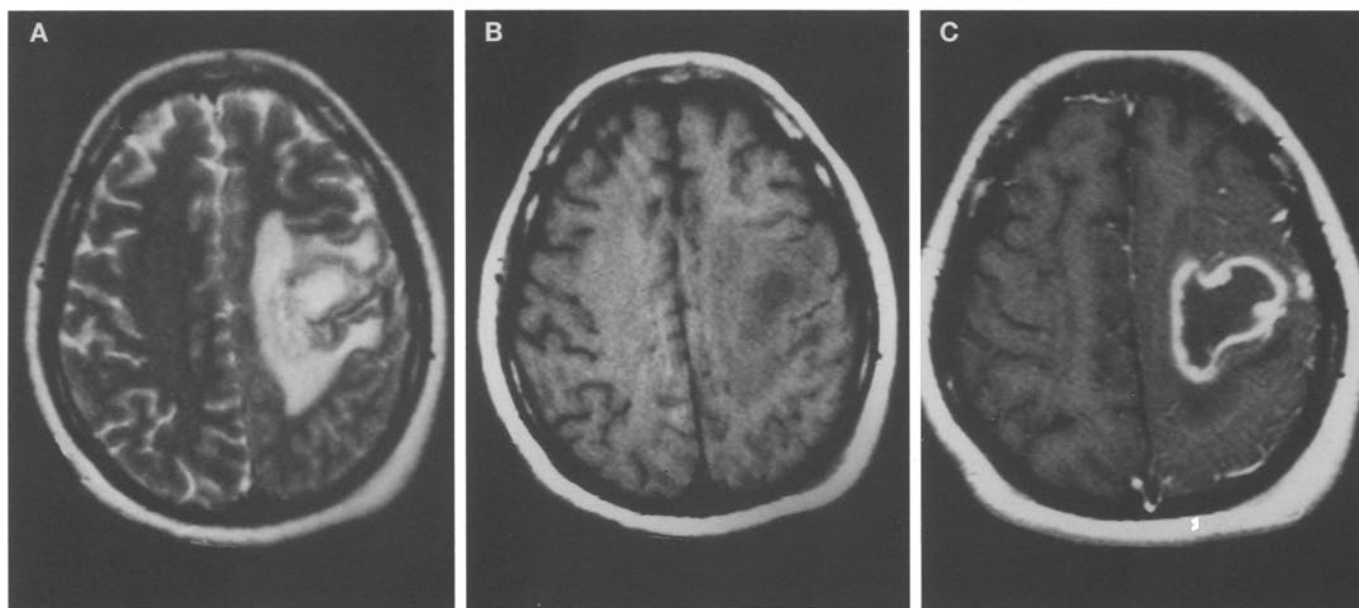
MRI revealing a space-taking lesion over left frontal-parietal lobe in T1 (A) and T2 (B) images and ring-like contrast enhancement with perifocal edema (C).
